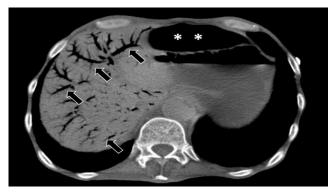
CT image of the abdomen without contrast material. There is widespread gas in the portal venous system in the liver (arrows). In addition, the image of free air in a large area of the stomach anterior is remarkable (asterisks).
